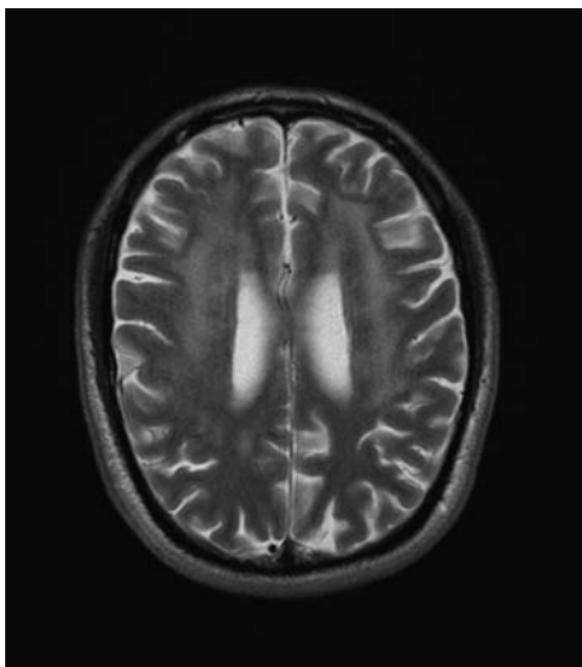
HIV encephalopathy (T2W axial MRI). Bilateral hyperintensity involving the cerebral white matter in association with volume loss denoted by prominence of the cerebral sulci.
